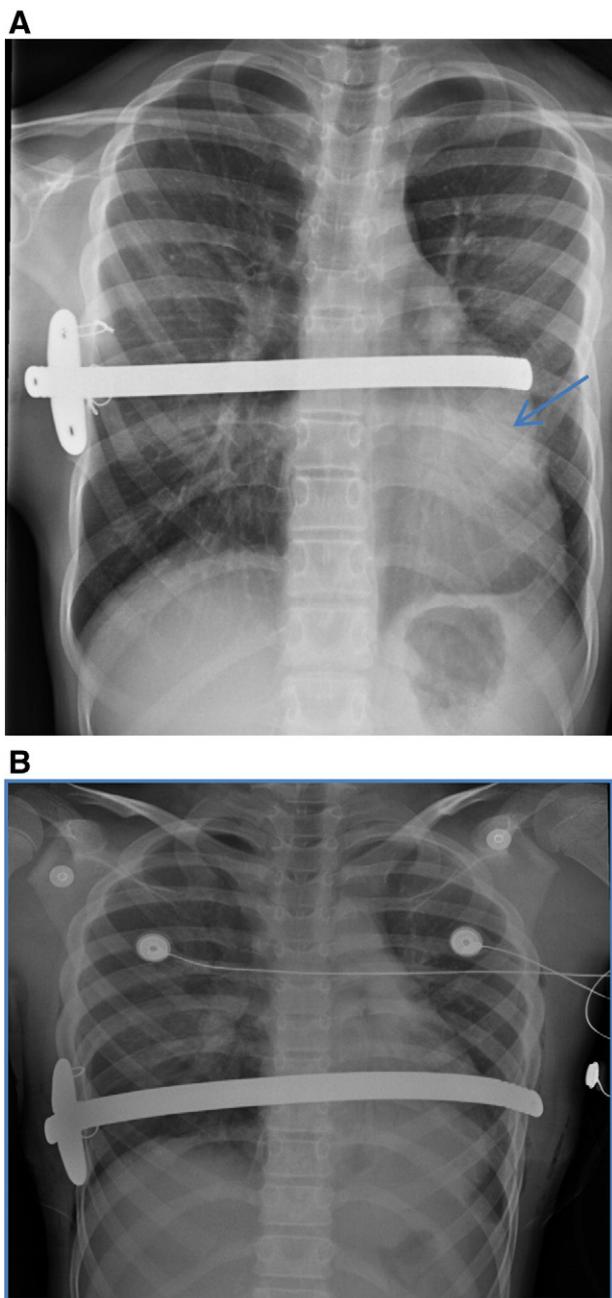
Chest roentgenograms in posterior–anterior view demonstrating prominent right ventricular outflow tract (arrow in A) which was absent in a chest x-ray obtained on the day of bar placement (2B).
